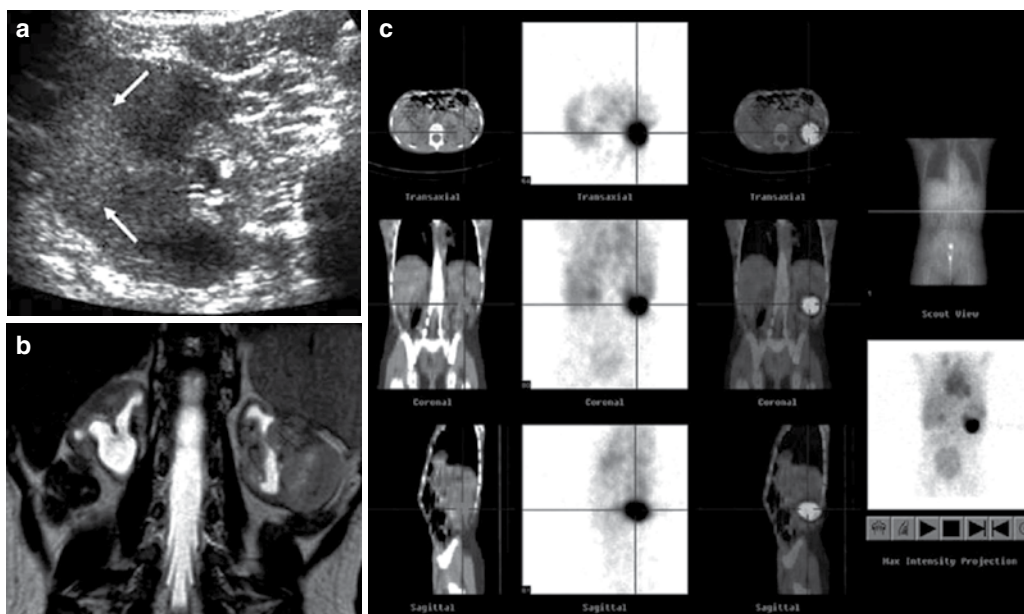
Localized pseudotumoral pattern of glomerular hyperfiltration in a case of reflux nephropathy. (a) US: transverse scan of the left kidney; hyperechoic ill-defined area in the external part of the kidney (marked by arrows). (b) MRU: T2-weighted sequence displays bilateral small irregular kidneys with distorted pelvicalyceal systems and a “tumoral” appearance of the left kidney. (c) Tc^{99m}-DMSA-SPECT-CT: the outer part of the left kidney highlights suggesting hyperfunction.
